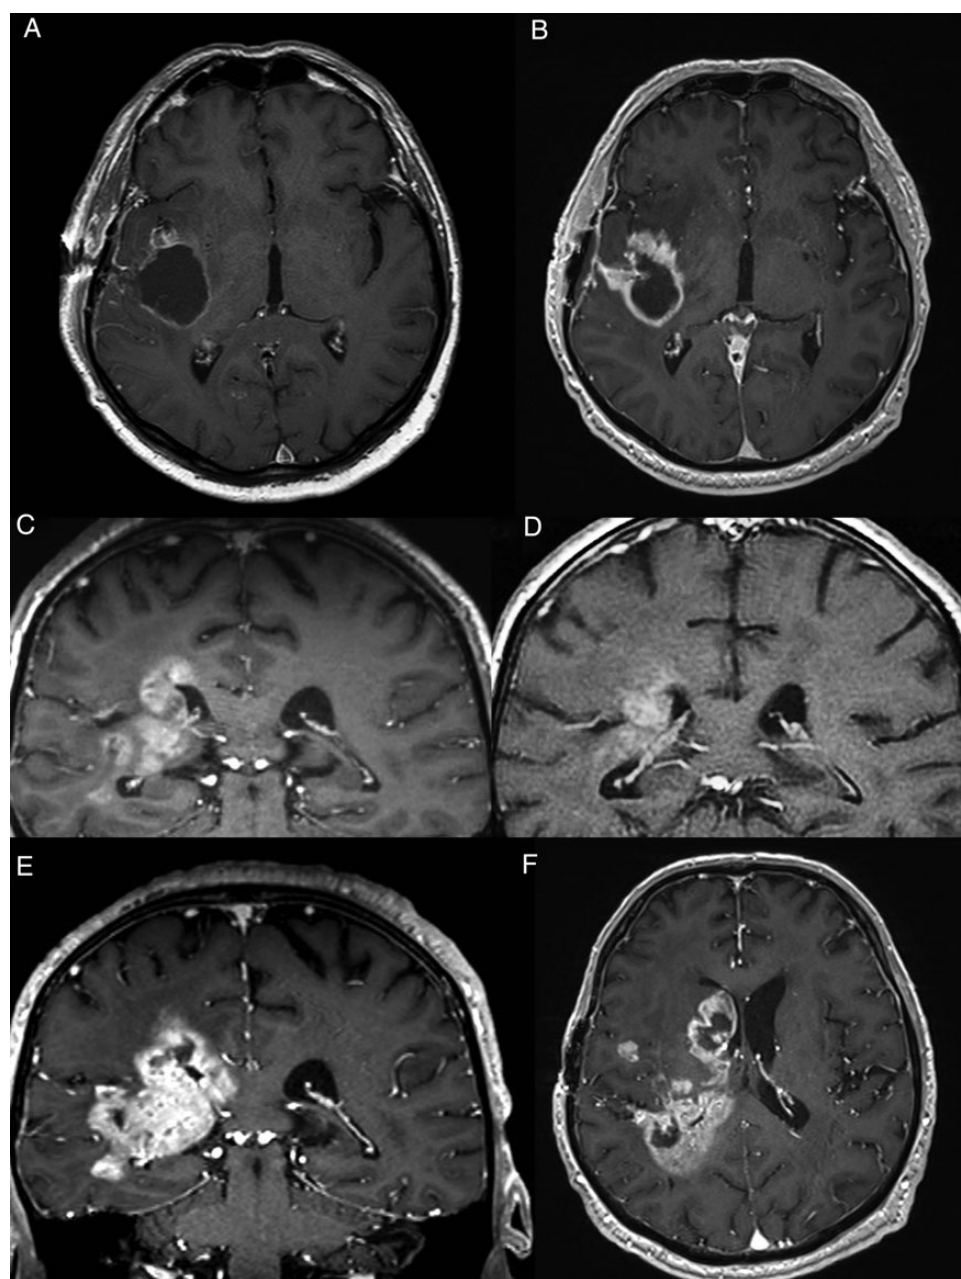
T1-weighted gadolinium-enhanced MRI sections. (A and B) Tumor progression after 2 cycles of adjuvant temozolomide (5/28 schedule). Transverse sections postoperatively (A) and 155 days postoperatively (B). (C and D) Tumor stabilization upon lomustine overdose. Coronal sections on day 3 (C) and on day 18 (D) relative to the first day of intake of 4 days times 200 mg lomustine. (E and F) Tumor progression on day 80 relative to the first day of intake of 4 days times 200 mg lomustine. Coronal (E) and transverse (F) sections.
